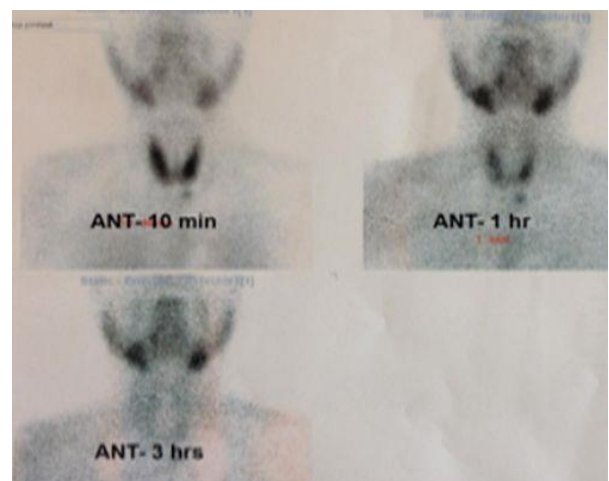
A lesion of the left lower parathyroid gland detected by 99mTc sestamibi scintigraphy.
